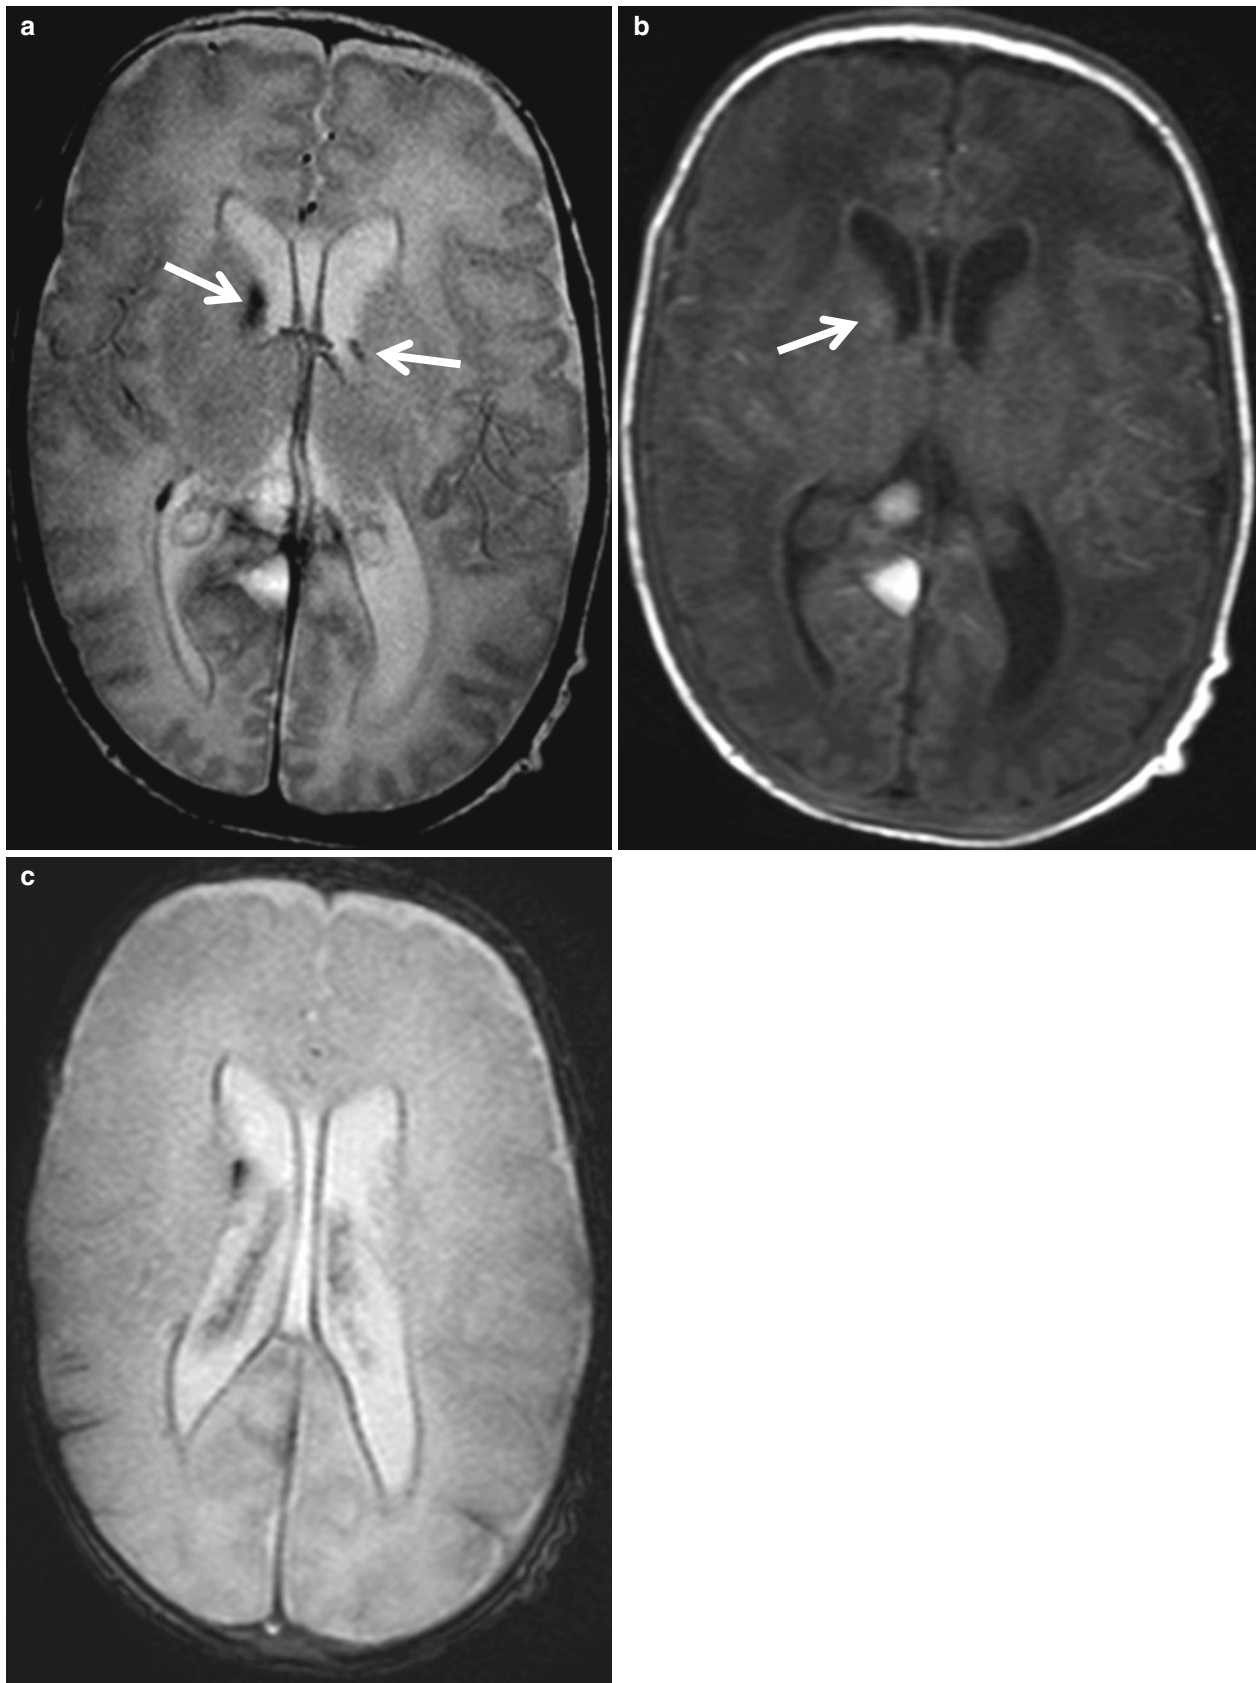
GMH-IVH in MR images. (a) GMH is seen as dark signal intensity on T2-weighted image. Dark signal intensity along the ventricular margin suggests hemorrhage. (b) On T1-weighted image, GMH
